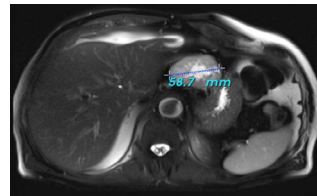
Abdominal MRI: Between the stomach and liver, mass lesion of 67x51 mm, whose borders are indistinguishable from the gastric wall, metastatic mass and cyst are observed
